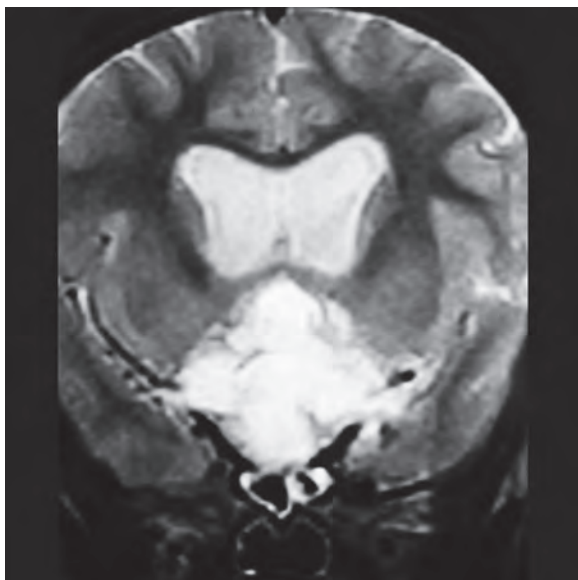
MRI of the brain coronal section showing hyperintense lesion involving the hypothalamus with dilated lateral ventricles
